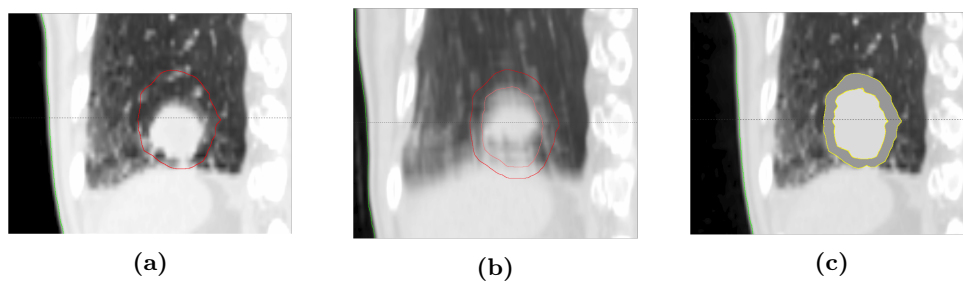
Overview of the investigated CT bases; (a) *St*, (b) *Avg*, and (c) *DO*.
